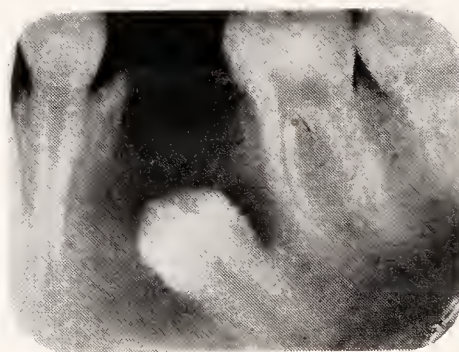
Radiograph of a dentigerous cyst that developed around the crown of an embedded lower bicuspid. (Ennis.)
